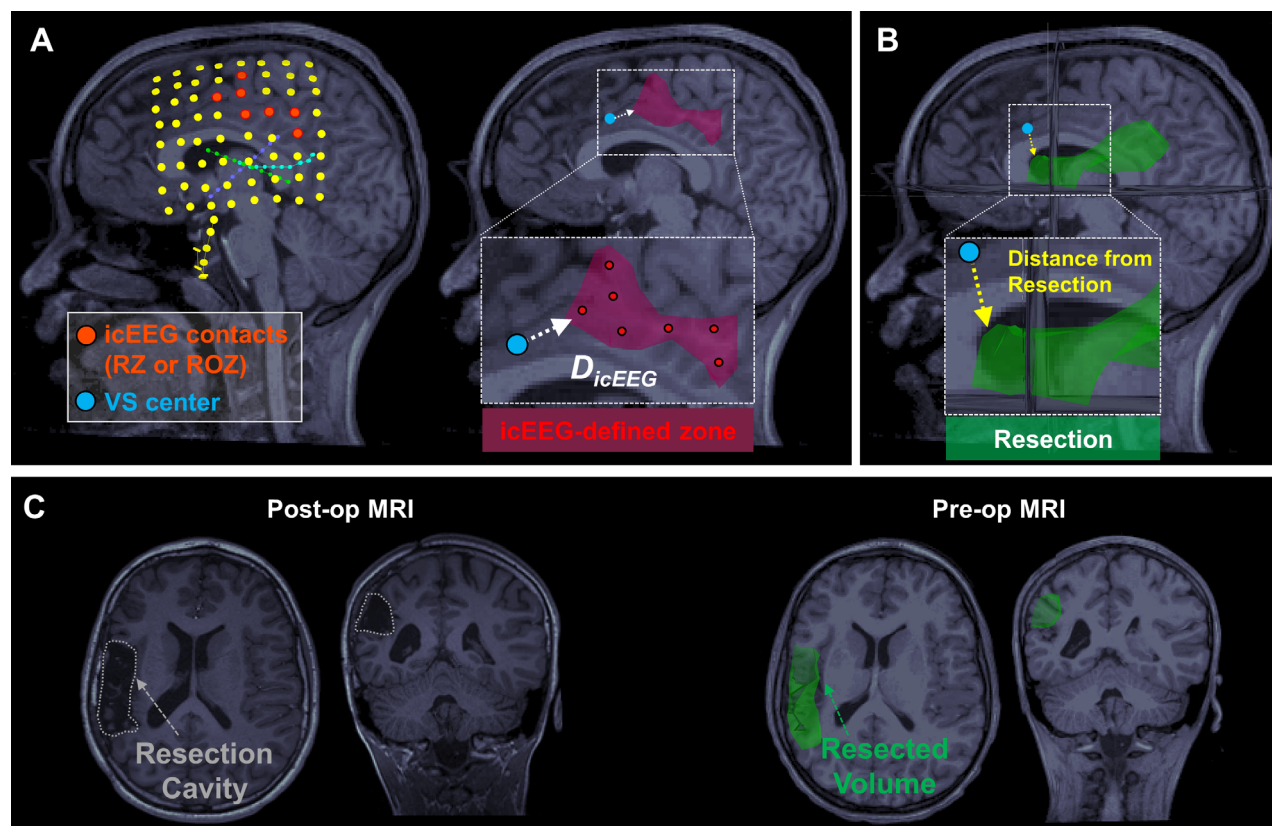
Comparison of virtual sensor (VS) estimates with invasive electroencephalography (EEG) and resection. (A) Left: Localization of intracranial EEG (icEEG) contacts on a patient's preoperative magnetic resonance imaging (MRI) after coregistration with postimplantation computed tomography. icEEG contacts recording high rates of ripples (or onset ripples) are marked in red. Right: Brain tissue surrounding the high-rate icEEG contacts (up to 10mm from their center) defines the invasive benchmark (red volume). D_{icEEG} is estimated as the distance between the VSs (light blue) recording a high rate of ripples (or onset ripples) and the icEEG-defined ripple zones (RZs; white arrow). (B,C) The resected volume (in green) was marked on the preoperative MRI after coregistration with postoperative MRI, where the resection cavity was identifiable. The distance of a VS from the resection was computed as its Euclidean distance from the closet margin of the resected volume (yellow arrow). ROZ = ripple onset zone.
